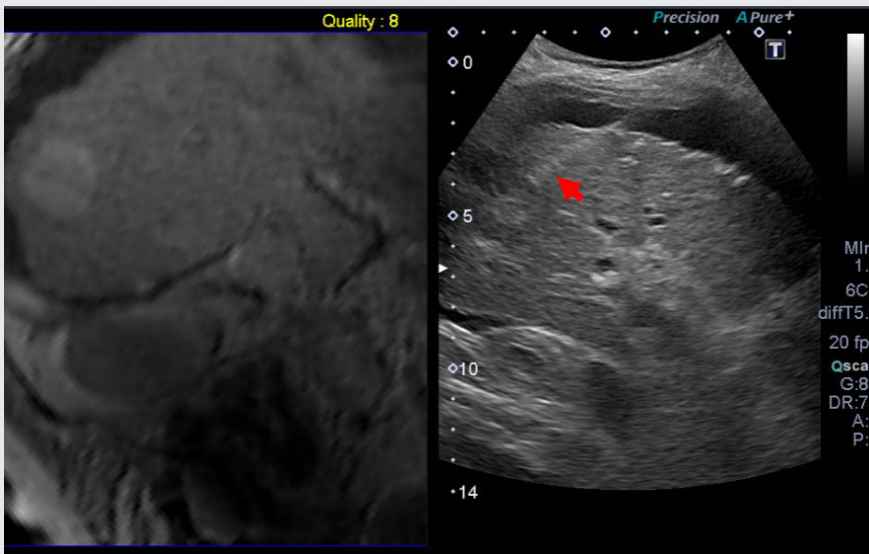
Synchronized MR image (left) and live ultrasound image (right) using Smart Fusion. The biopsy needle (red arrow) is clearly visualized in the live ultrasound image.
